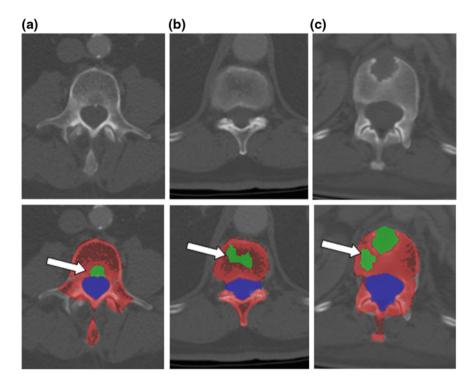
False positive detections in lytic metastasis CAD. *First row* CT image; *Second row* false positive detections. a Basivertebral vein; b vertebral disk; and c volume averaging
